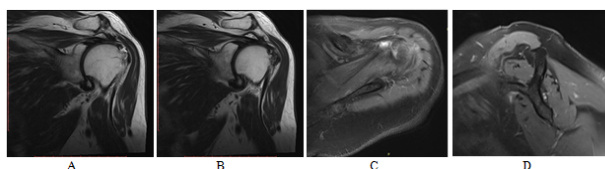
Preoperative magnetic resonance imaging view of the left shoulder. A, B. In the coronal view large rotator cuff tear with an anterosuperior supraspinatus tendon retraction; C. In the axial view, the supraspinatus tendon displays a retracted full-thickness tear; D. In the parasagittal view-supraspinatus muscular atrophy is present.
